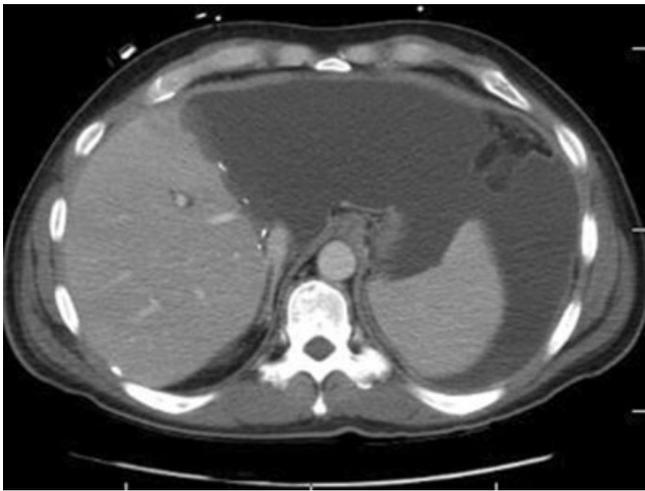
Contrast-enhanced CT demonstrating the biliary necrosis secondary to hepatic artery thrombosis (HAT). The arrows depict dilated, ischemic bile ducts. A drainage catheter (circle) is present within the dilated left ducts. The drainage from this was purulent.
